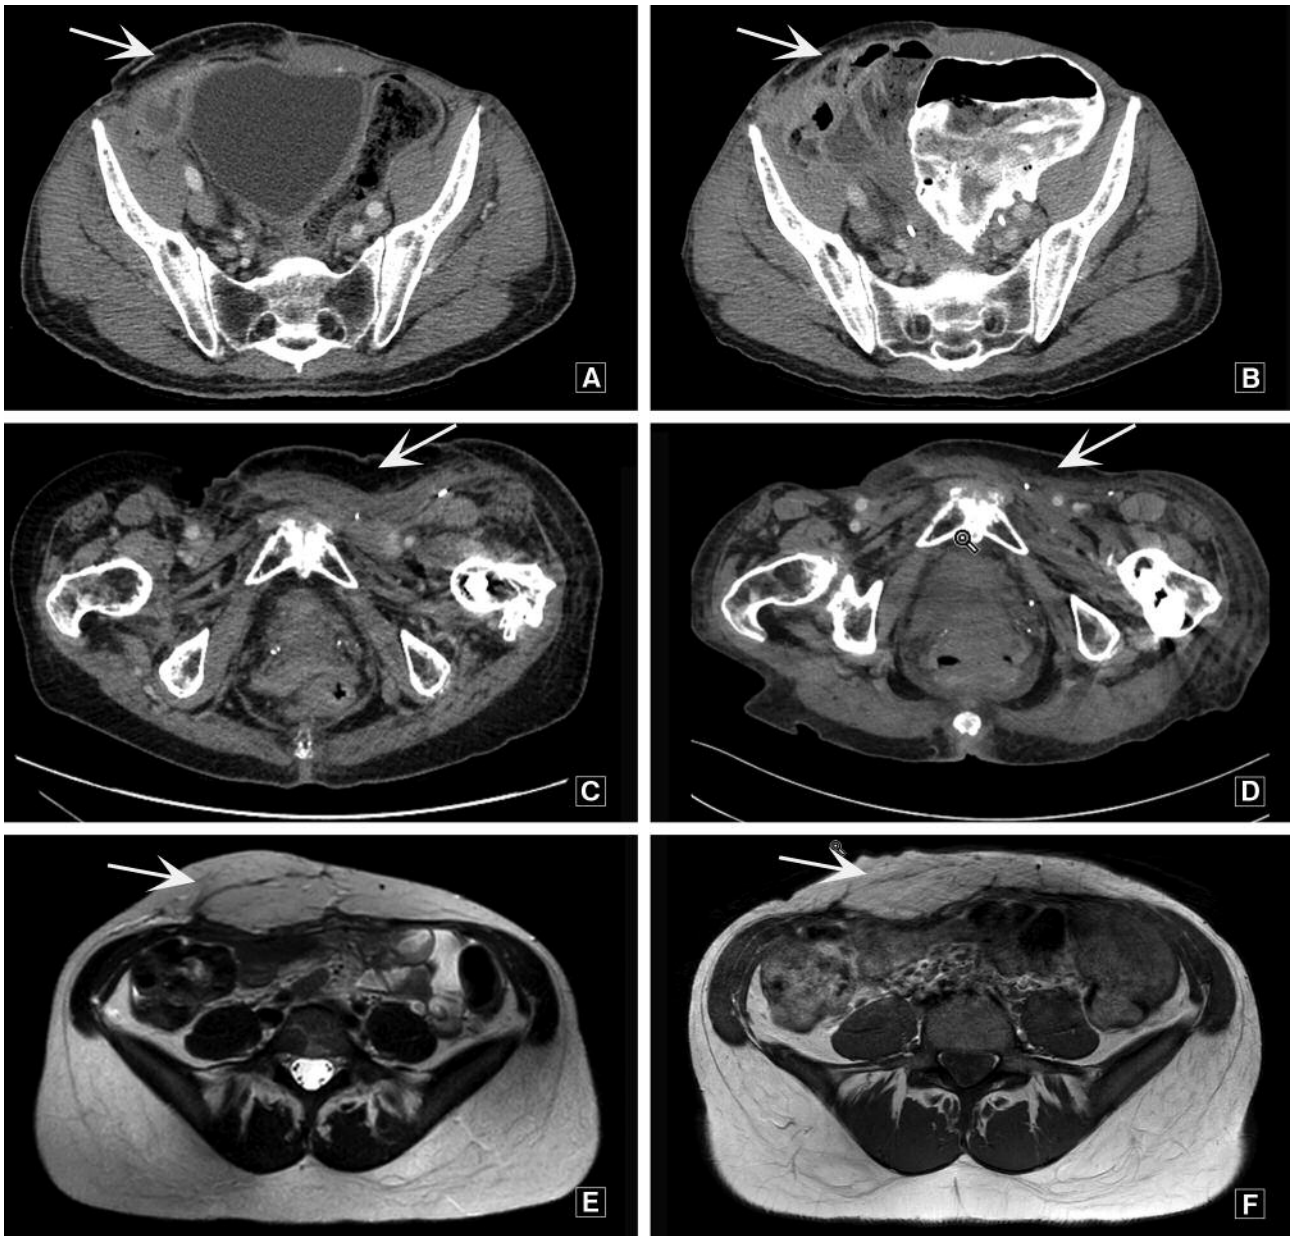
Serial imaging showing the ALT flap (white arrow) resorption over time. Serial CT scans at follow-up of patient 2 (preserved innervation) after pedicled ALT reconstruction for a 3-dimensional abdominal defect. Six months postoperative (A). 12 months postoperative (B). Serial CT scans at follow-up of patient 5 (denervated) after pedicled ALT reconstruction for a 3-dimensional abdominal defect. Six months postoperative (C). At 12 months postoperative (D). Serial MRI at follow-up of patient 10 (reinnervated) after free ALT reconstruction for a 3-dimensional abdominal defect. Six months postoperative (E). At 12 months postoperative (F).
